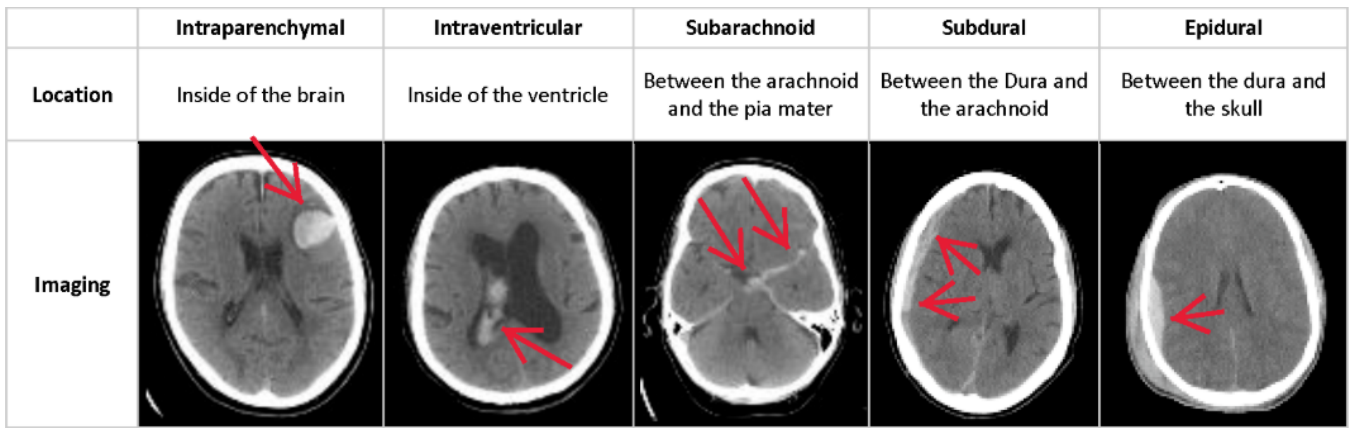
CT Scans of Different Types of ICH
